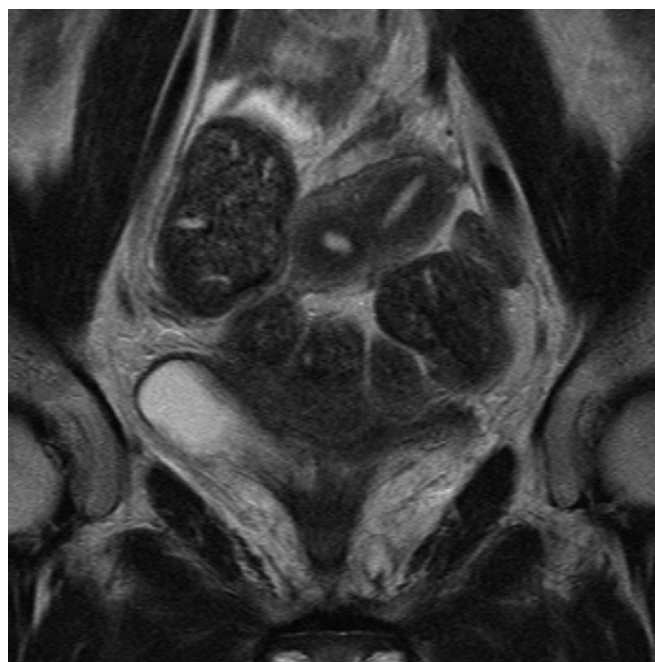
Coronal T2-weighted magnetic resonance image of the pelvis, showing 2 endometrial cavities separated by a septum. The contour of the uterine fundus is flat, with no fundal cleft present.
